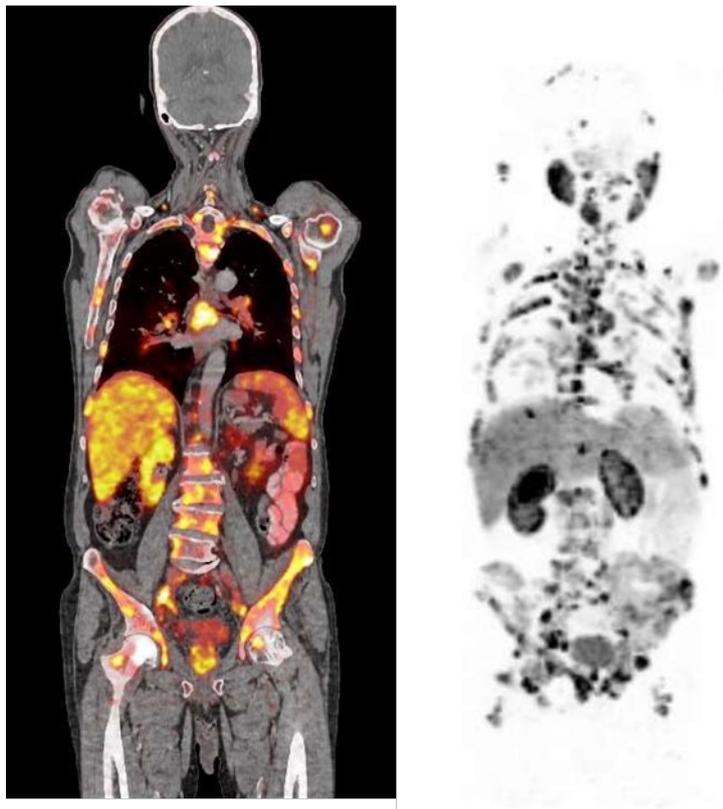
(A) and (B): 68 Yr-old male with adenocarcinoma of the prostate presented with prostatic involvement, retroperitoneal lymph nodes and extensive skeletal metastases. Patient was initially treated with ADT followed by radiotherapy. Present PSMA PET/CT shows recurrent disease involving prostate with multiple skeletal metastases.
